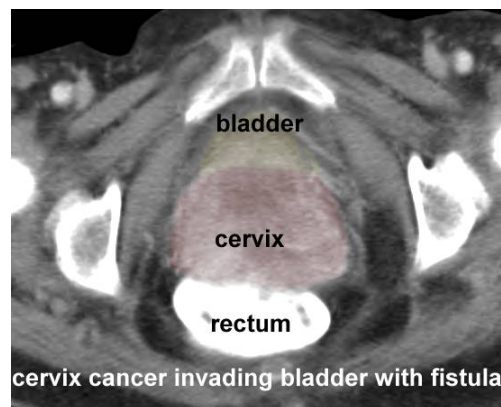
Transversal CT scan of cervix cancer with organs highlighted.[53]
